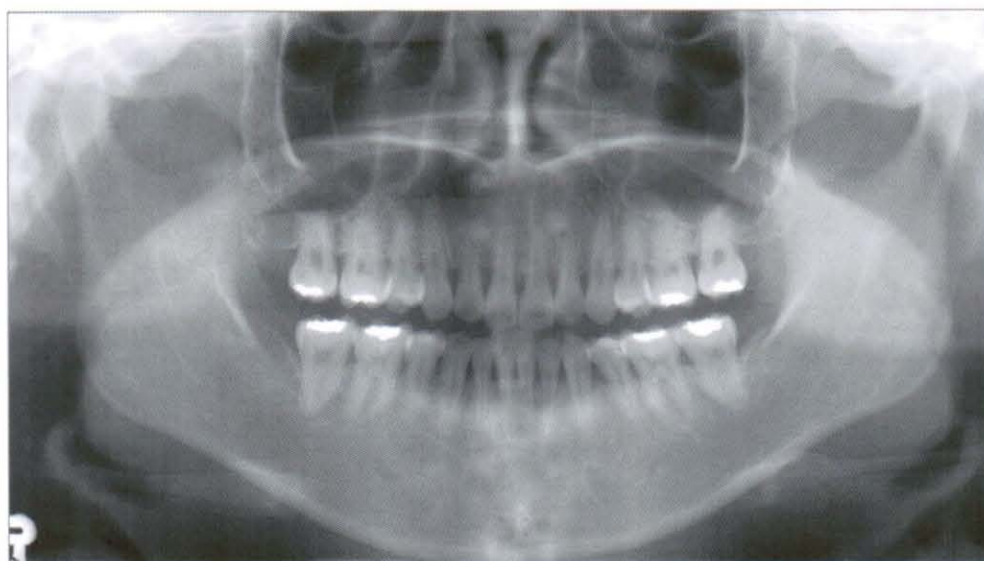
Panoramic radiograph at 22 months post-retention (2005, 12,6)
